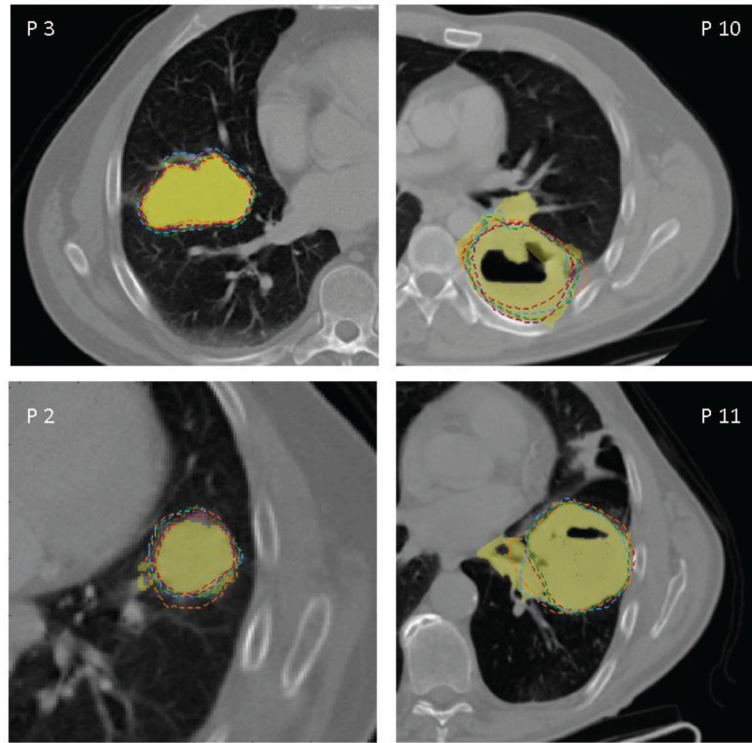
Representative CT images of NSCLC patients. Lung tumors were segmented using a click and grow ensemble segmentation algorithm (yellow solid color wash) and manually delineated by five independent observers (color dotted lines).
